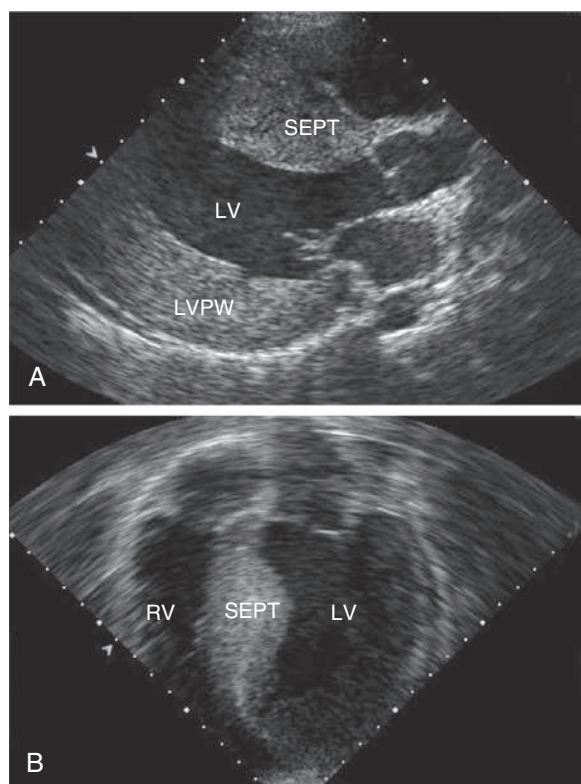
Echocardiograms demonstrating hypertrophic cardiomyopathy. A, Parasternal long-axis view of a patient with severe concentric left ventricular hypertrophy. B, Four-chamber view of a patient with asymmetric septal hypertrophy. LV, Left ventricle; LVPW, left ventricular posterior wall; RV, right ventricle; SEPT, septum.
